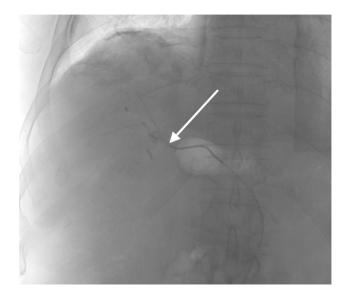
Gadolinium contrast injection for C-arm computed tomography. The white arrow demonstrates the catheter tip with injection into the right hepatic artery.
